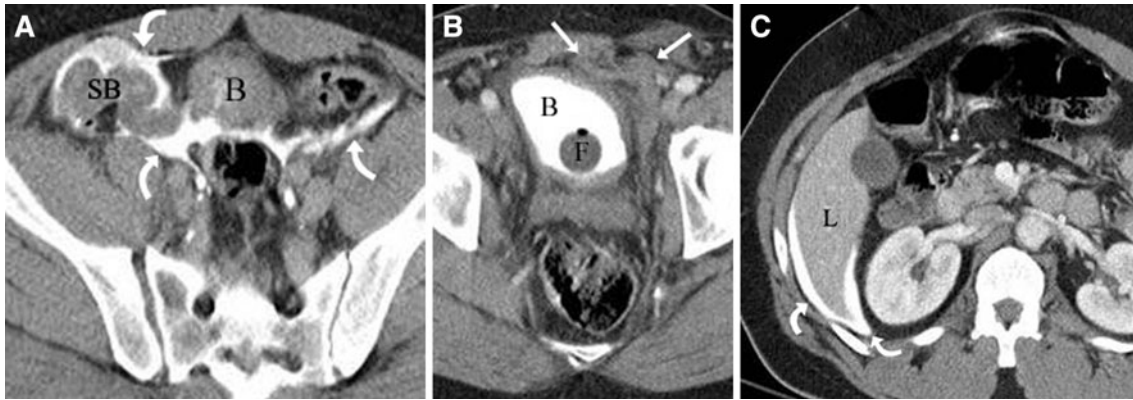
A 58-year-old male status post-blunt abdominal trauma. A Axial contrast-enhanced CT of the upper pelvis demonstrated contrast material (*curved arrows*) adjacent to the bladder (*B*) and surrounding a loop of small bowel (*SB*) in the right lower quadrant. B Axial contrast-enhanced CT of the pelvis demonstrated bladder (*B*)
